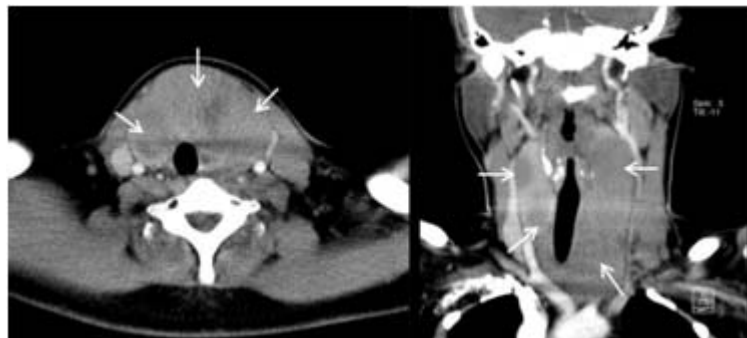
Lymphoma of thyroid gland. Axial and coronal enhanced CT scan showed diffuse thyroid gland enlargement with several hypodense masses (arrows). Diffuse large B-cell lymphoma of thyroid gland was proved by pathology.
